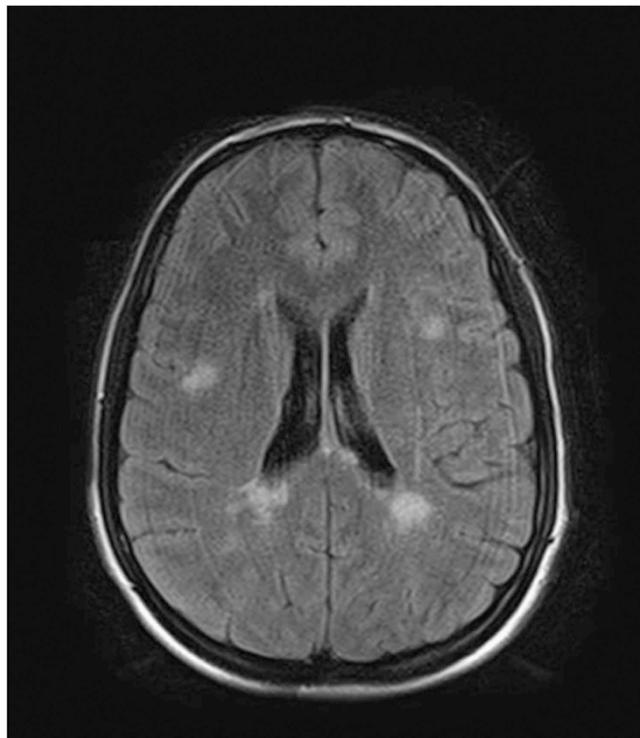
Axial T2-flair-weighted brain MRI showing multiple demyelinating lesions suggestive of MS.
